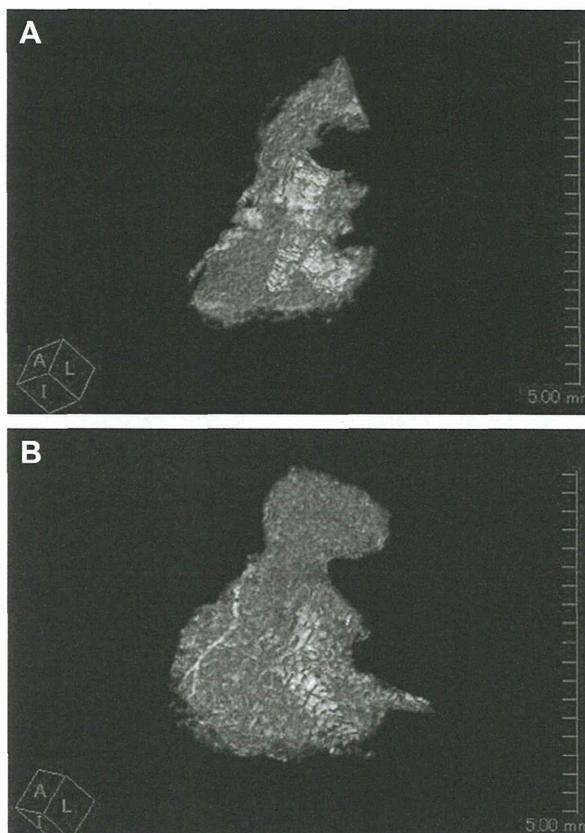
The three-dimensional computed tomography volumetric changes in a 42-year-old male donor before (A) and after distal pancreatectomy (B).
